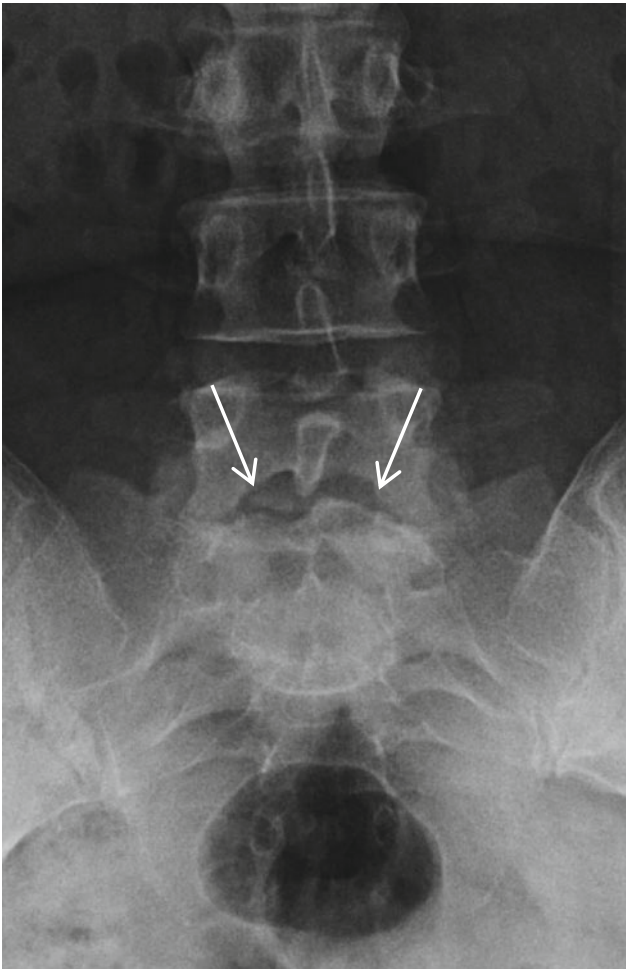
AP X-ray of the lumbar spine in a 25-year-old woman displaying normal appearance of Cupid's bow of the inferior endplate of L5 (arrows)
